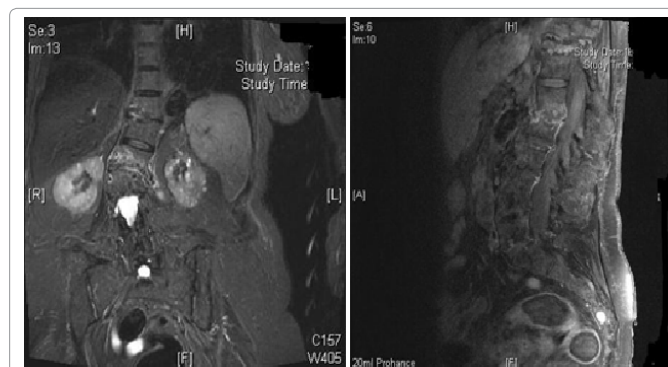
MRI Images at admission. Showing high signal of disc space and adjacent tissues, suggestive of spondylodiscitis in the Thoracic spine between D11/D12 and lumbar spine at L1/L2 disc space with bone oedema, blurry edges of the endplates of the mentioned discs and a compromised spinal canal along with degenerative scoliosis.
